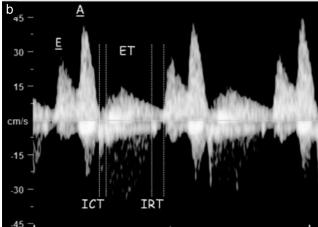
Spectral Doppler images of ventricular inflow and outflow obtained from the left (a) and right (b) ventricles, respectively. Utilizing the technique described by Hernandez-Andrade *et al.*¹³, time intervals can be measured by placing the cursors on the valve clicks (bars). On the left side of the heart the interval between the closure of the mitral valve and the opening of the aortic valve marks the isovolumetric contraction time (ICT). The ejection time (ET) is the interval between aortic valve opening to closure, and the isovolumetric relaxation time (IRT) is the time interval between aortic valve closure and mitral valve opening (a). On the right side of the heart the same intervals can be determined utilizing the tricuspid and pulmonary valves (b). The myocardial performance index for the left and right ventricles was calculated using the formula (ICT + IRT)/ET. The same views were utilized to calculate the early/atrial (E/A) ratios between early passive ventricular filling.
